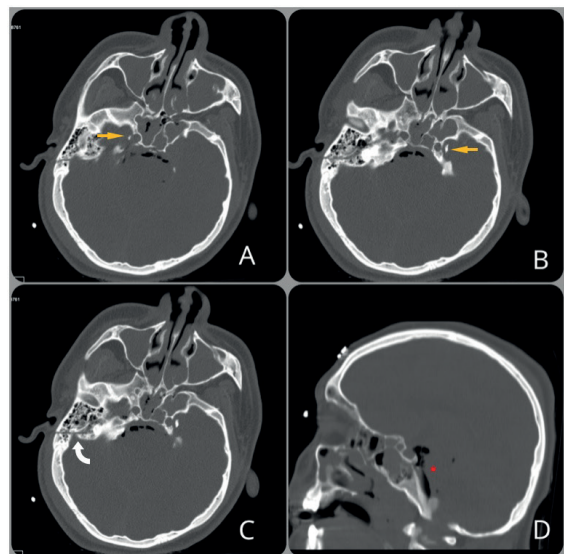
Initial head CT reveals multiple fractures in skull base including lateral walls of carotid canals on both sides. On image A and B yellow arrows depict the separated osseous fragments. On image C, curved arrow shows longitudinal fracture of right temporal bone. On image D, pneumocephalus (red star) is demonstrated.
